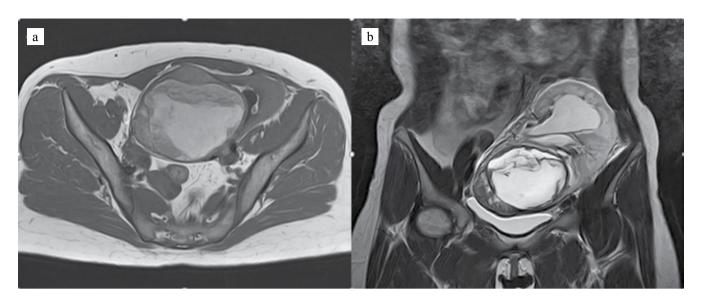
MRI of an allograft kidney with renal sinus tumor: a, axial image; b, frontal image
